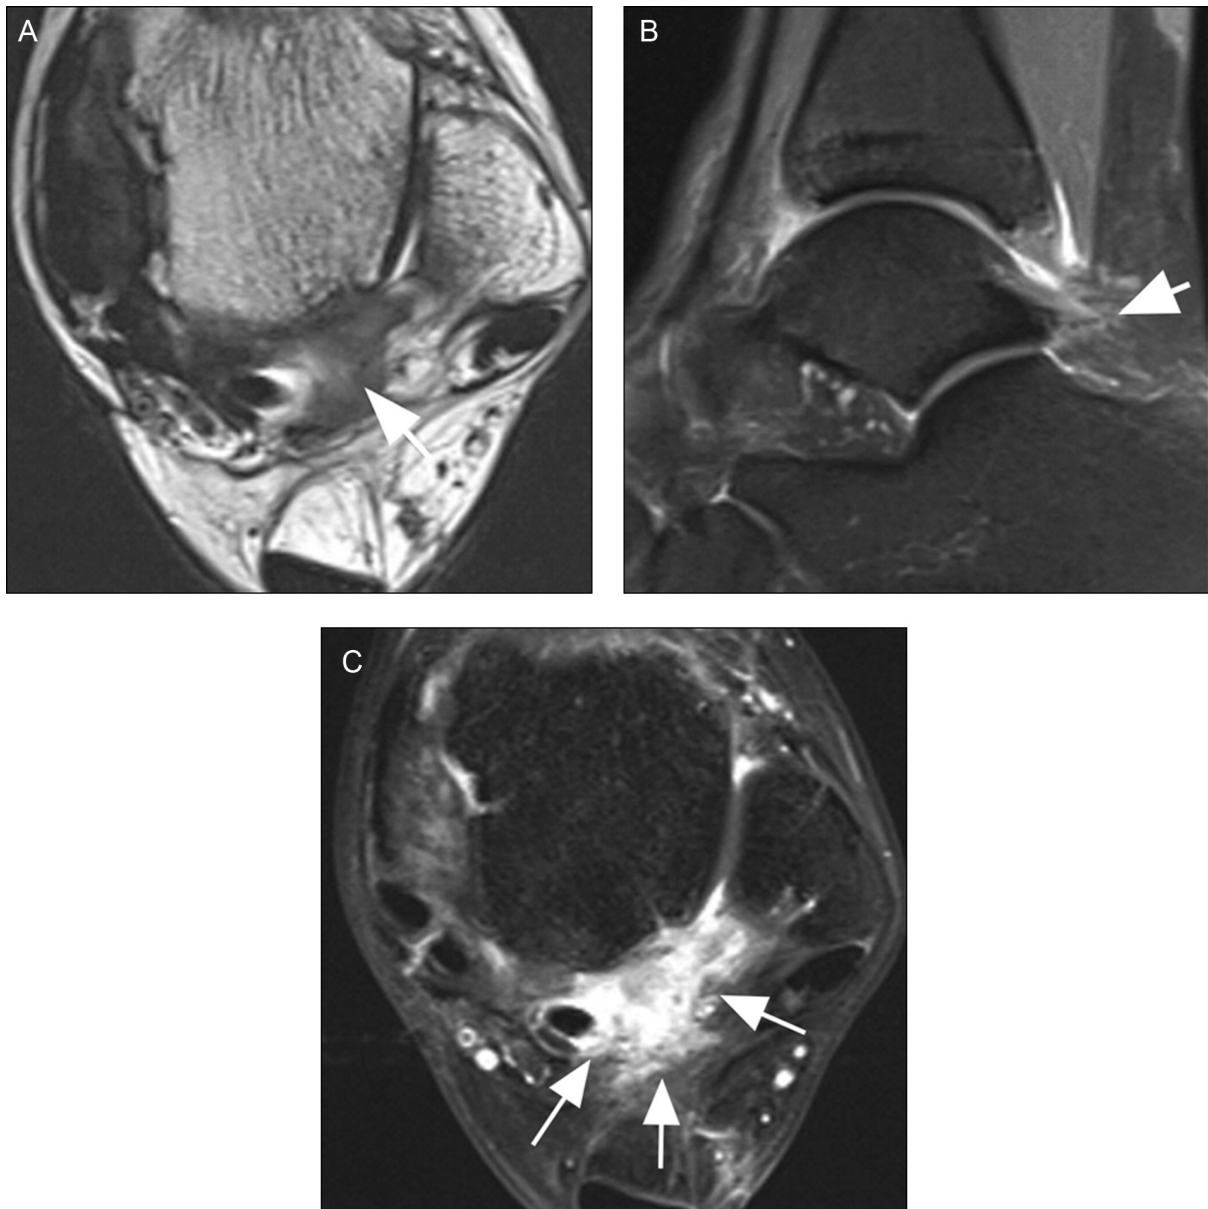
A 23-year-old professional female dancer with posterior ankle pain. (A) Axial T2-weighted MRI shows diffuse hypointensity posteriorly to the talus likely representing circumscribed fibrosis (arrow). (B) Sagittal proton density-weighted fat-suppressed MRI depicts minimal hyperintensity in the same anatomical region (short arrow). (C) Axial contrast-enhanced T1-weighted fat-suppressed MRI shows intense enhancement demonstrating focal posterior capsulitis as the source of the pain (arrow). Note that no os trigonum or other anatomical predisposing structures are present in this patient.
